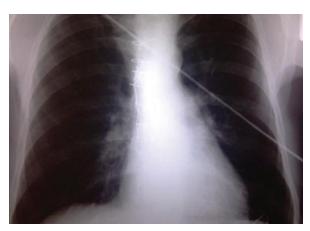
Chest radiograph after the procedure shows the left atrium to be greatly reduced in size.
